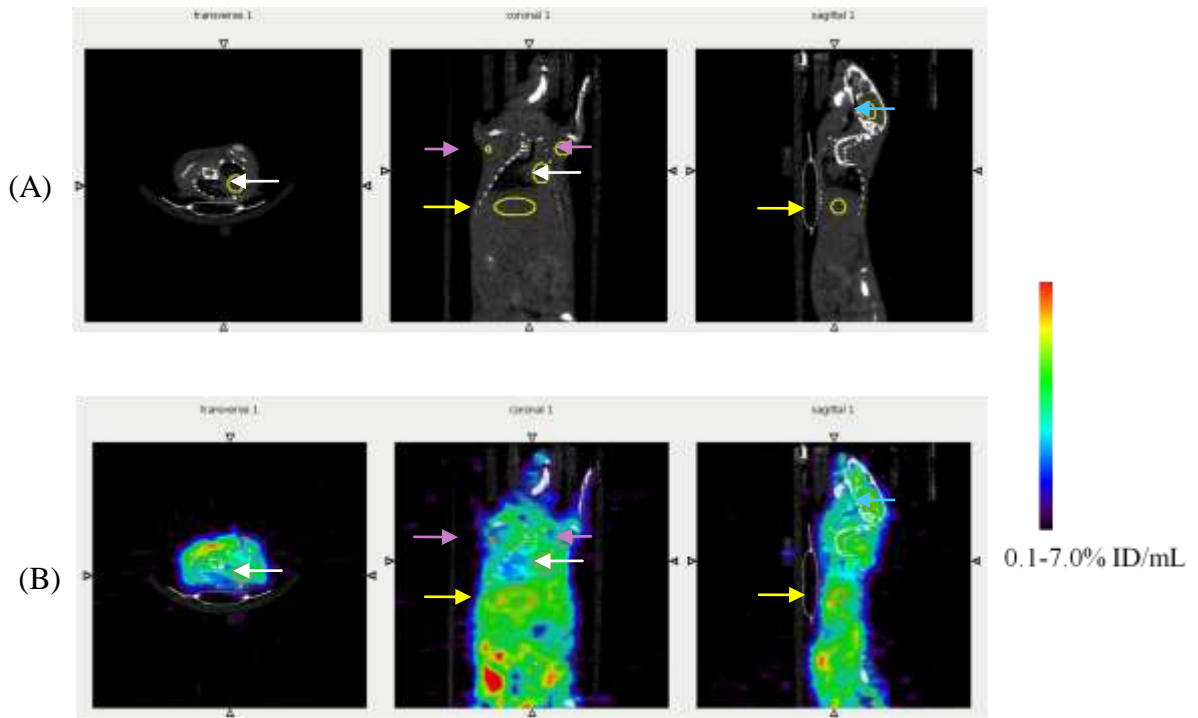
Dynamic PET image 65-66 minutes pi: ROIs for heart (transverse and coronal view, white arrow), muscle left and right (coronal view, purple arrow), and liver (coronal and sagittal views, yellow arrow). (A) CT image (B) PET/CT image. PET colour indicating 0.1-7% ID/g
